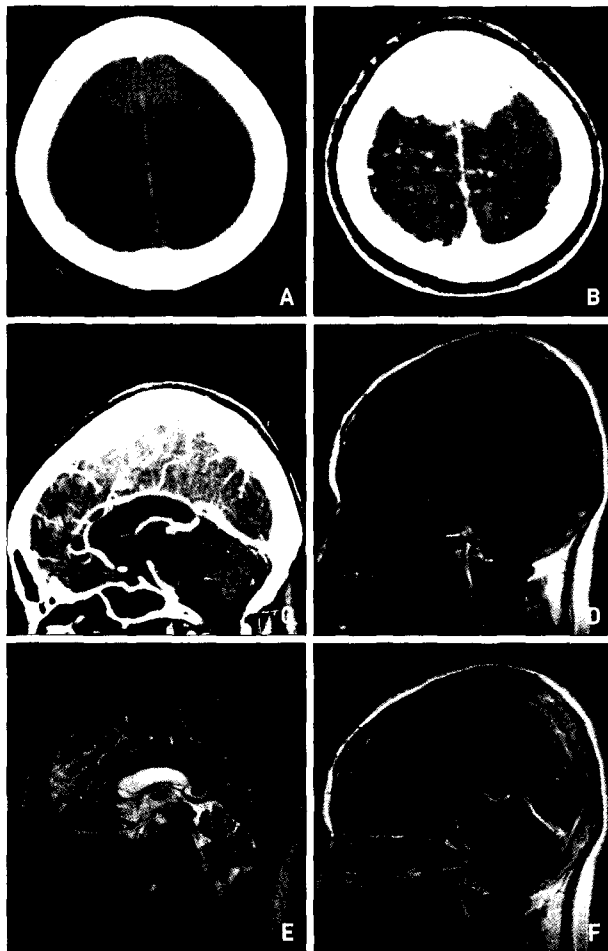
Computed tomography shows a slightly high-density mass in high frontal convexity (A) and broad-based mass of dura with contrast enhancement at axial (B) and sagittal (C) image. Magnetic resonance image (MRI) scans show a mass which demonstrates iso-signal intensity in T1-weighted (D) images, low signal intensity in T2-weighted (E) magnetic resonance images. T1-weighted gadolinium-enhanced MRI shows a homogeneously enhancing lesion. The mass had a broad base in the dura (F).
